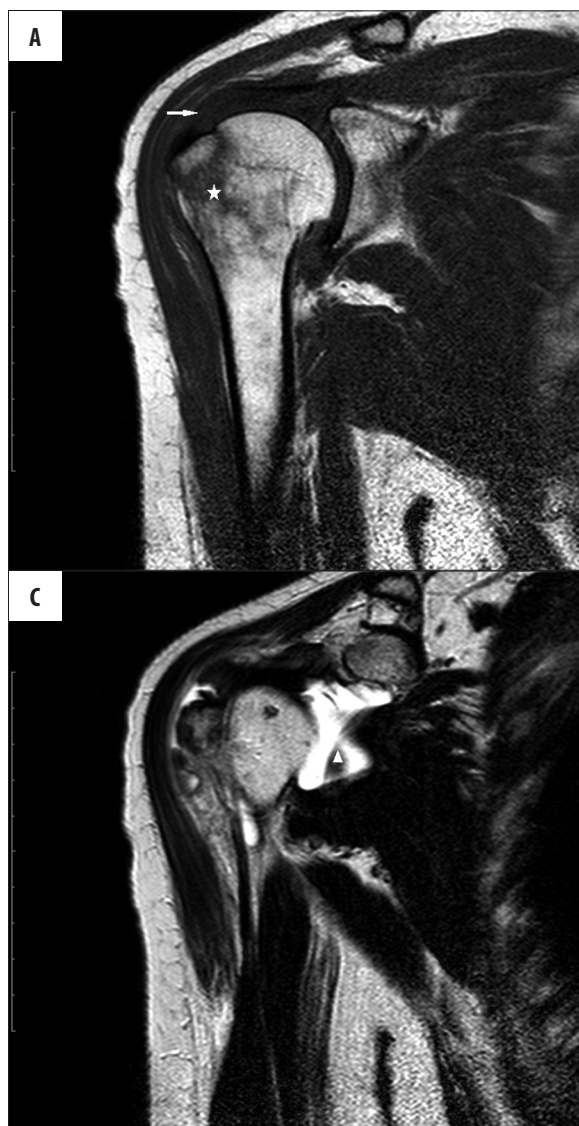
Shoulder MRI. (A) T1-weighted image, frontal plane. (B) T2-weighted image, frontal plane. Anterior supraspinatus tendon thinning, partial tear above the attachment to greater tubercle (arrow). Posttraumatic changes of lesser and greater tubercles, bone marrow (star) and surrounding soft tissue edema. (C) T2-weighted image, frontal plane. Increased volume of intraarticular fluid (arrow head).
